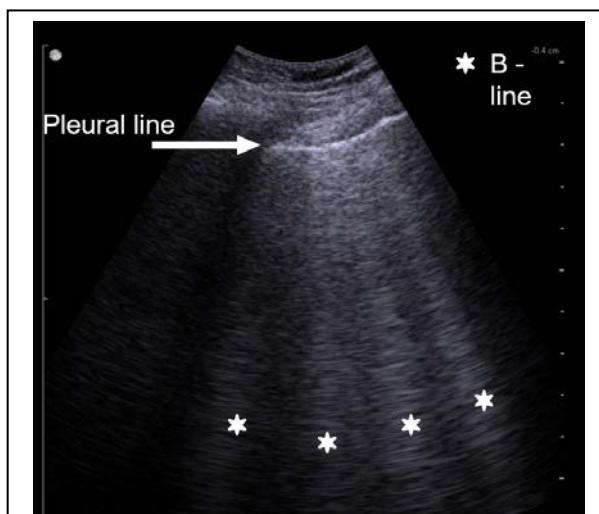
Pathologic lung ultrasound with three or more B-lines in one region.
